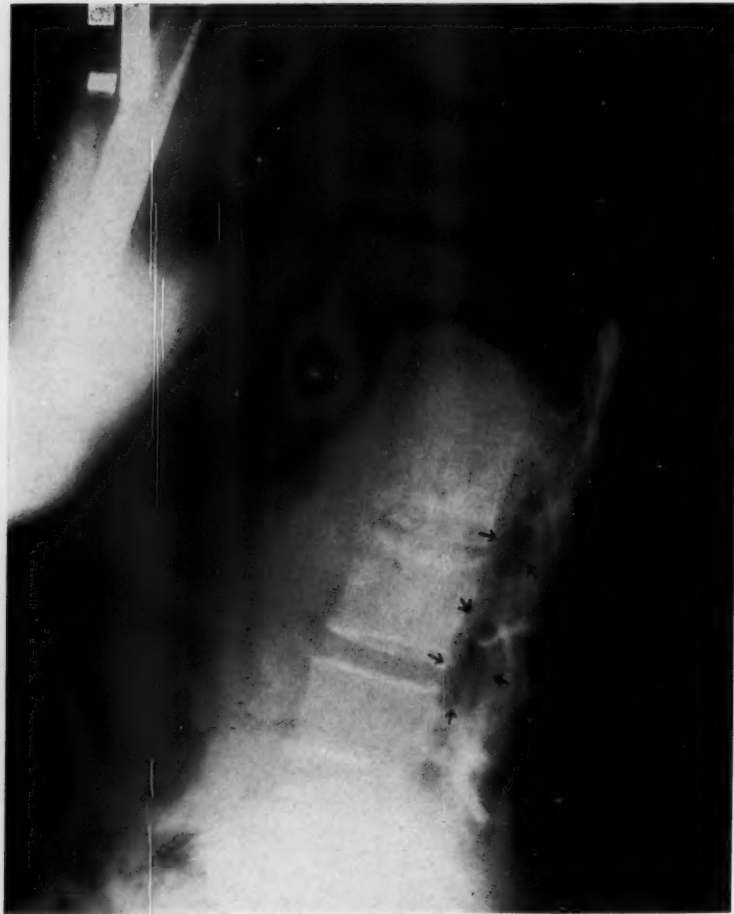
Reproduction of X-ray negative showing air in the spinal subarachnoid space denoting the lower level of the subarachnoid block.
